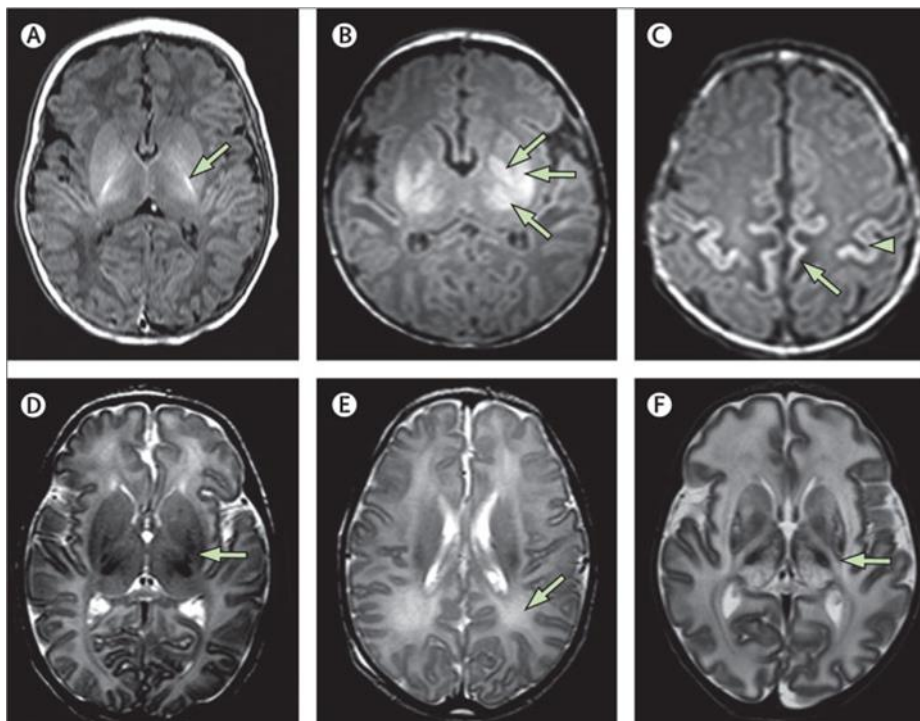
MRI appearance in neonatal hypoxic–ischaemic encephalopathy⁽²⁰⁾
